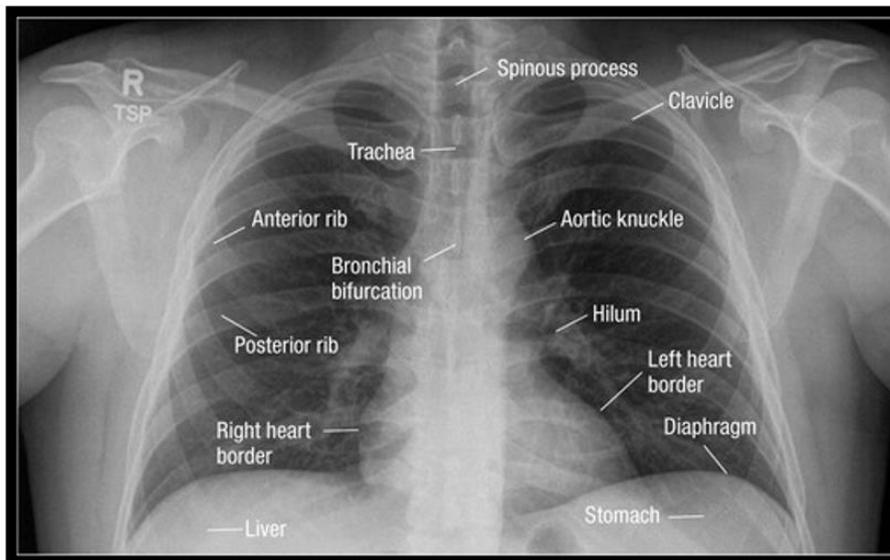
Demonstration of aortic knuckle in chest X-ray PA view^[6]
